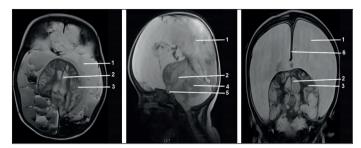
Patient's MRI done at the arrival to our clinic (1-subdural hematoma 2-shrunken ventricle, 3-atrophic cortex, 4-cerebellum 5-atrophic diencephalon 6-falx).
